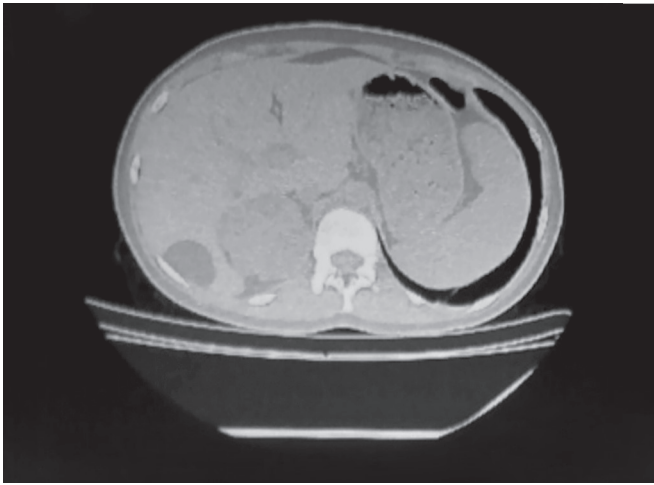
Computed tomography abdomen showing hepatic angiomyolipoma
